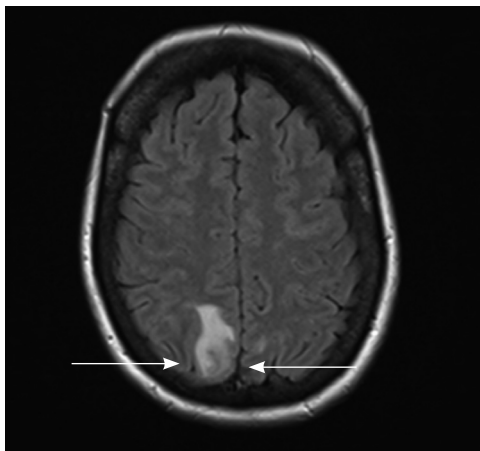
Magnetic resonance imaging of the brain demonstrating a confluent FLAIR signal abnormality within the posterior right frontal lobe with a tiny amount of FLAIR hyperintensity present within the posterior left frontal lobe, consistent with posterior reversible encephalopathy syndrome.
